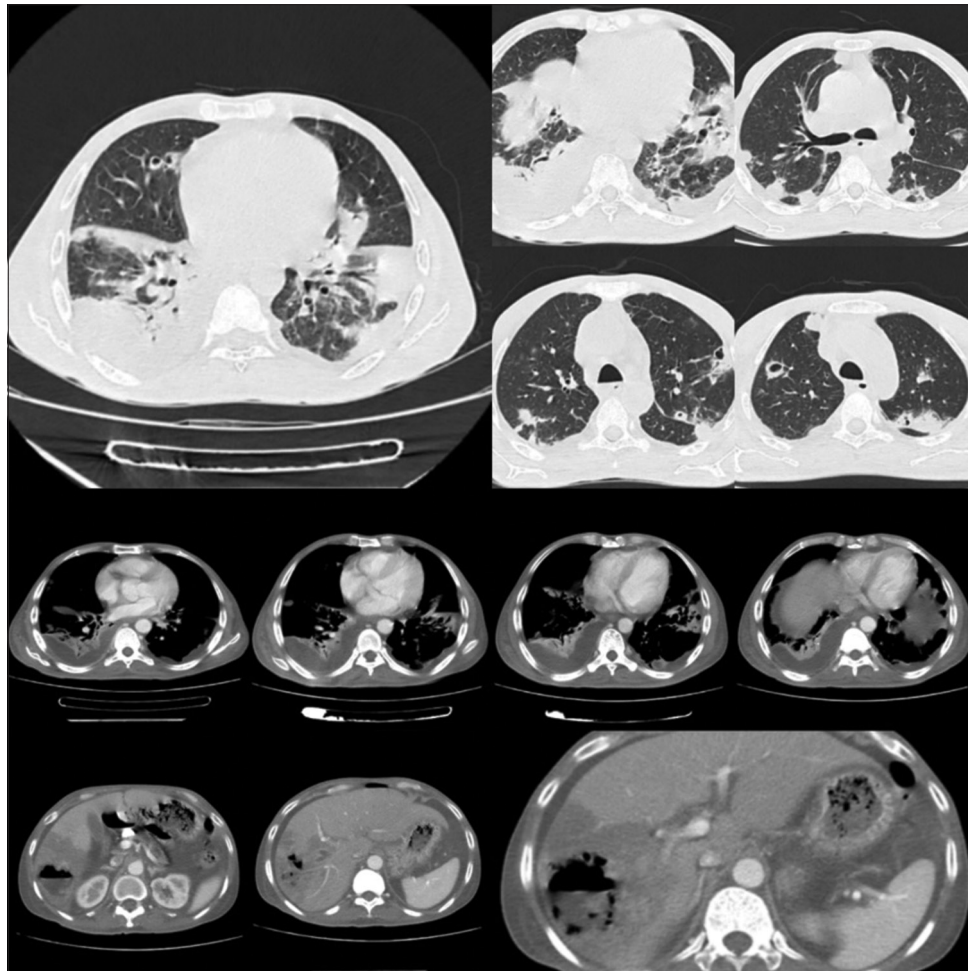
Contrast-enhanced computed tomography of the thorax and abdomen demonstrating multiple air foci in bilateral lungs with an abscess in the right lobe of liver
